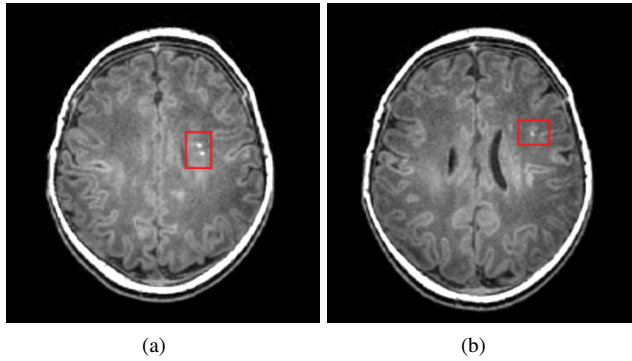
Lesions in neonatal T1 MRI. The lesions are in a red rectangle which is very clear.
